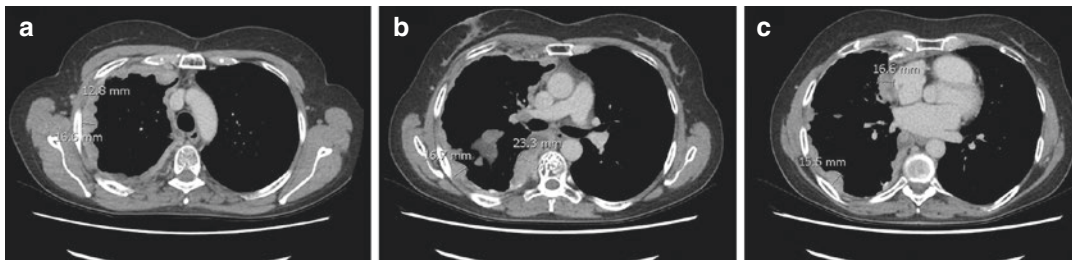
(a–c) Two unidimensional measurements have been taken perpendicular to the chest wall or mediastinum on each of three axial CT slices, to give six measurements
